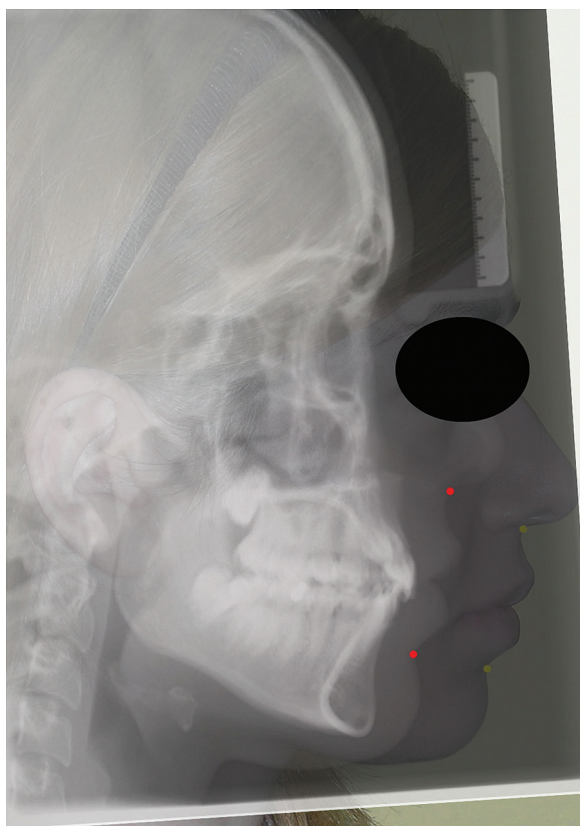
Superimposition of lateral cephalometric radiograph on profile photograph.
